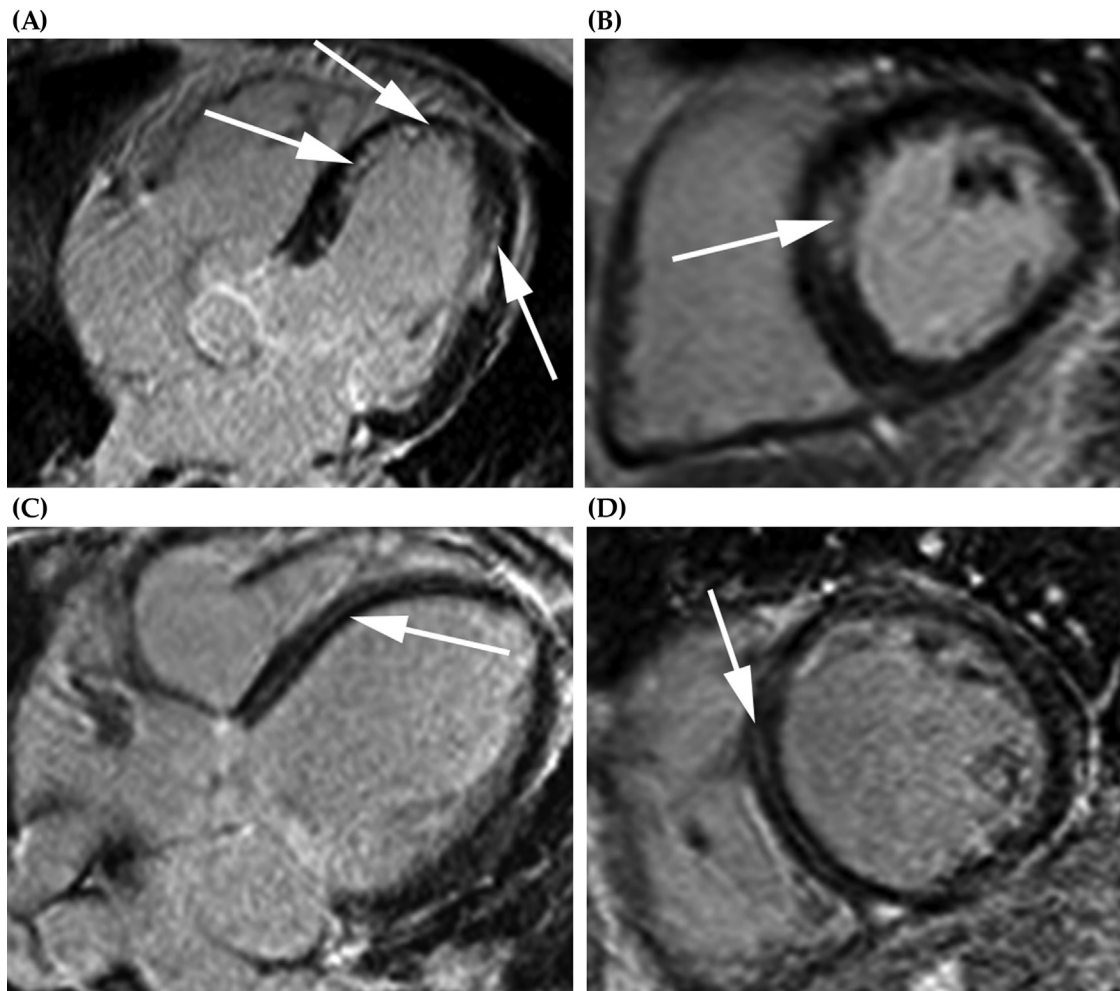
Cardiac MRI of two representative EGPA patients and their LGE patterns. Diffuse subendocardial LGE in a 56-year old EGPA patient, demonstrated in 4-chamber (A) and short-axis plane (B). Midmyocardial LGE in a 61-year old EGPA patient, demonstrated in 4-chamber (C) and short-axis plane (D). *Adapted from the personal collection of the authors.*
